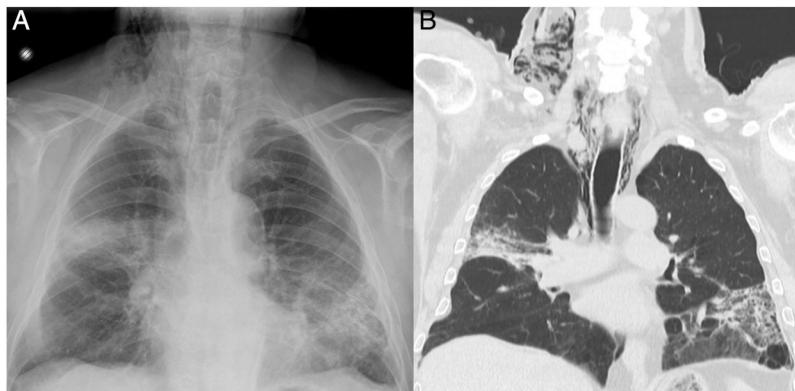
(A) Posteroanterior chest X-ray showing subcutaneous emphysema and persistent pulmonary consolidations in the RUL and LUL. (B) CT coronal reconstruction showing predominantly right-sided pneumomediastinum and subcutaneous emphysema in the cervical region.
